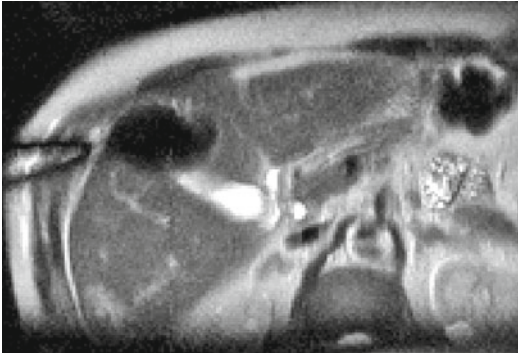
Ice ball formation around two cryoprobes in the liver as depicted on a T2-weighted image acquired in 600 ms (LoLo technique) (Image courtesy of Prof. Dr. med. J. Tacke, Passau Hospital, Germany)
